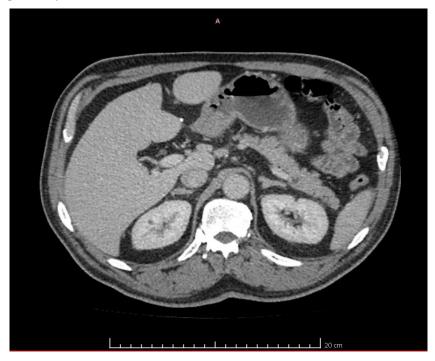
Axial plane section on computed tomography showing a fishbone still within the liver parenchyma without an abscess around it.
